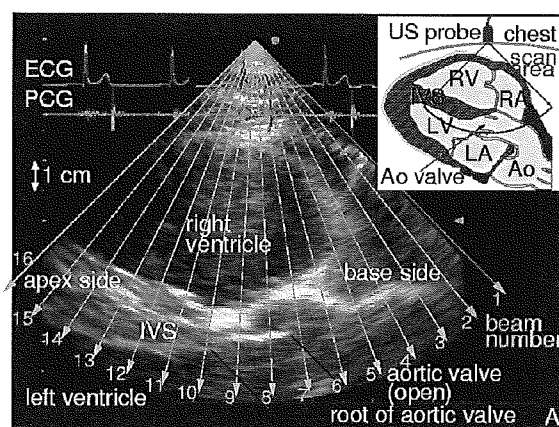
upper: A cross-sectional image measured by conventional echocardiography in a healthy young male (subject A). The arrows show the directions of the 16 ultrasonic beams used to measure the vibrations at about 160 points in the heart wall. lower: For the man at two points set along the 13th ultrasonic beam, each waveform for six consecutive cardiac cycles is overlaid.
